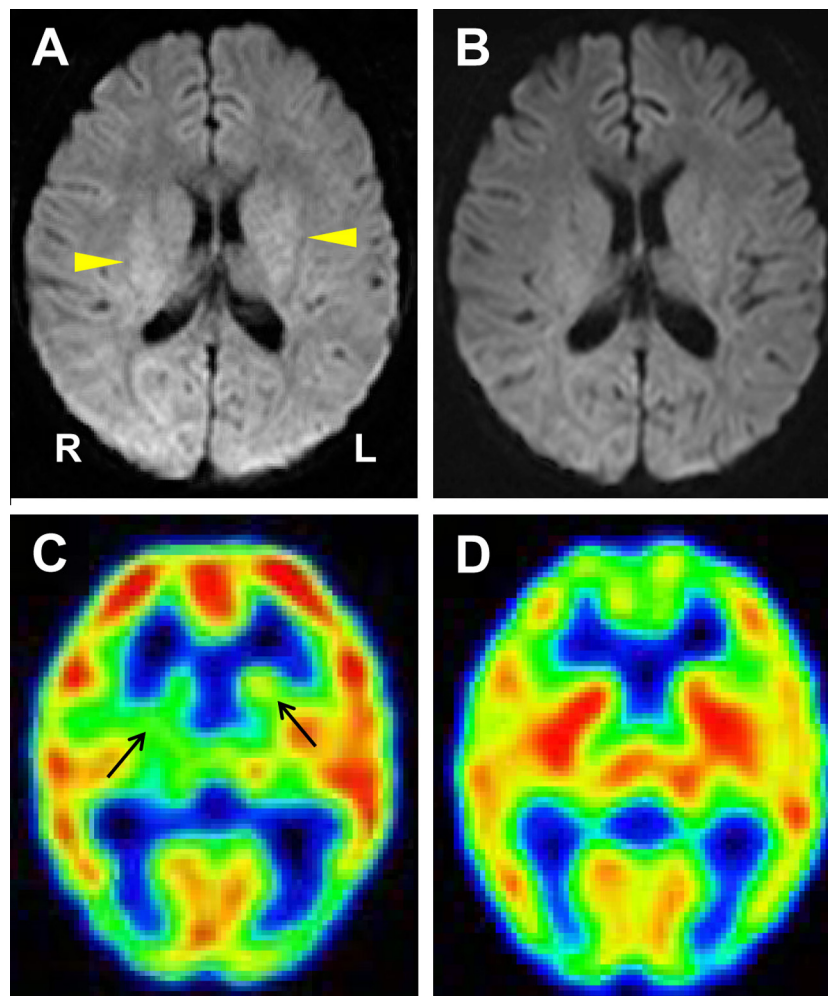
Neuroimaging studies on day 11 (A, C) and around a month (B, D) of illness. Diffusion-weighted imaging ( $b$  value = 2000 s/mm<sup>2</sup>) demonstrates right-dominant bilateral lesions in the striatum (A), which resolves thereafter (B). Single-photon emission computed tomography reveals hypoactivity in right-dominant bilateral lesions in the striatum (C). The lesions improve, but diffuse hypoactive areas emerge in the bilateral frontal lobes (D).
